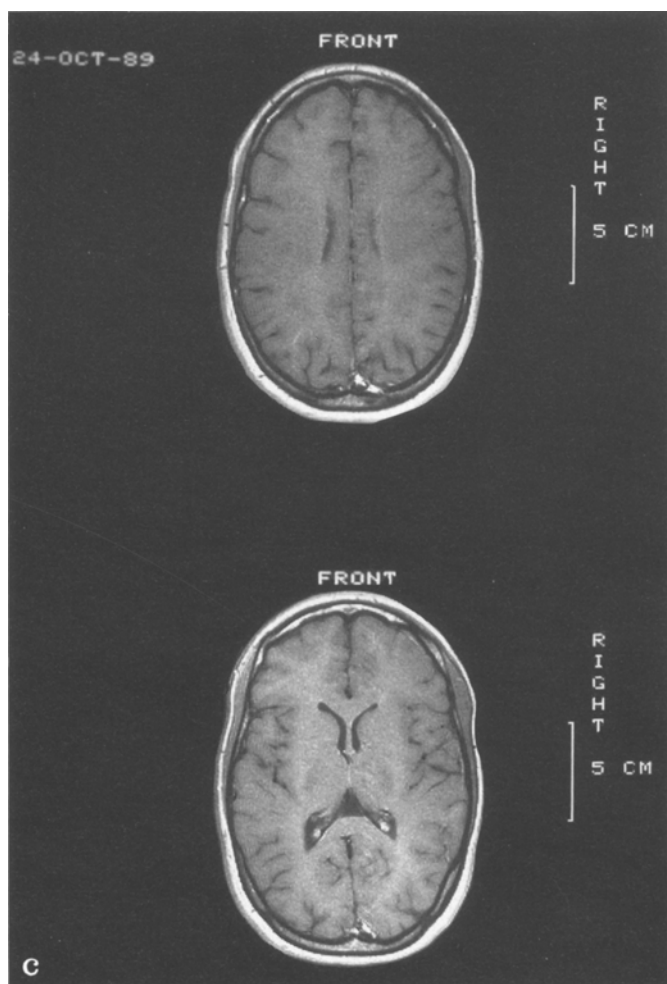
Gadolinium-MRI follow-up in patient 4: a first scan before treatment, showing a small enhancing lesion on the left parietal lobe and a larger lesion on the right occipital lobe; b third scan taken during an acute relapse, 3 months after the beginning of treatment, showing multiple enhancing lesions in both hemispheres; c control-scan after 9 months without local Gadolinium enhancement
